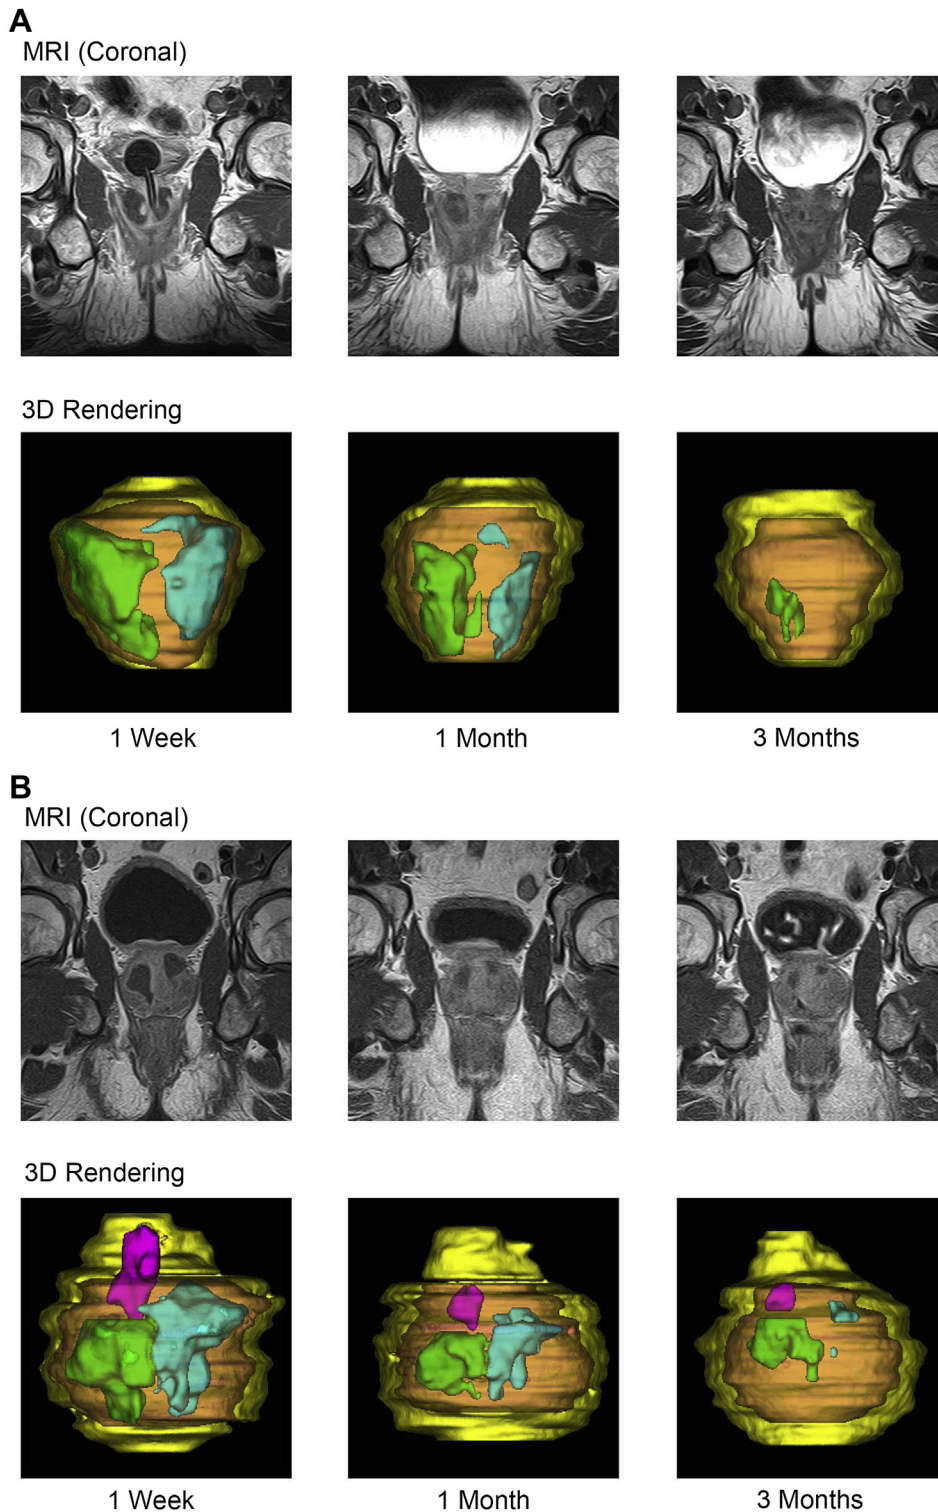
Magnetic resonance imaging of lesions generated by convective water vapor energy and their resolution after treatment. Three-dimensional renderings correspond to magnetic resonance imaging coronal views. Represented are the transition zone (orange) and lesions within the right lateral lobe (green), the left lateral lobe (blue), and the median lobe (pink). (A) Outcome at 1 week, 1 month, and 3 months after procedure demonstrating coalesced, contiguous lesion defect in a 39-cm³ prostate. (B) Outcome demonstrating more significant lesion defects in an 89-cm³ prostate. In both cases, by 3 months, most of the lesion volume had been resorbed. MRI, magnetic resonance imaging; 3D, 3-dimensional.
